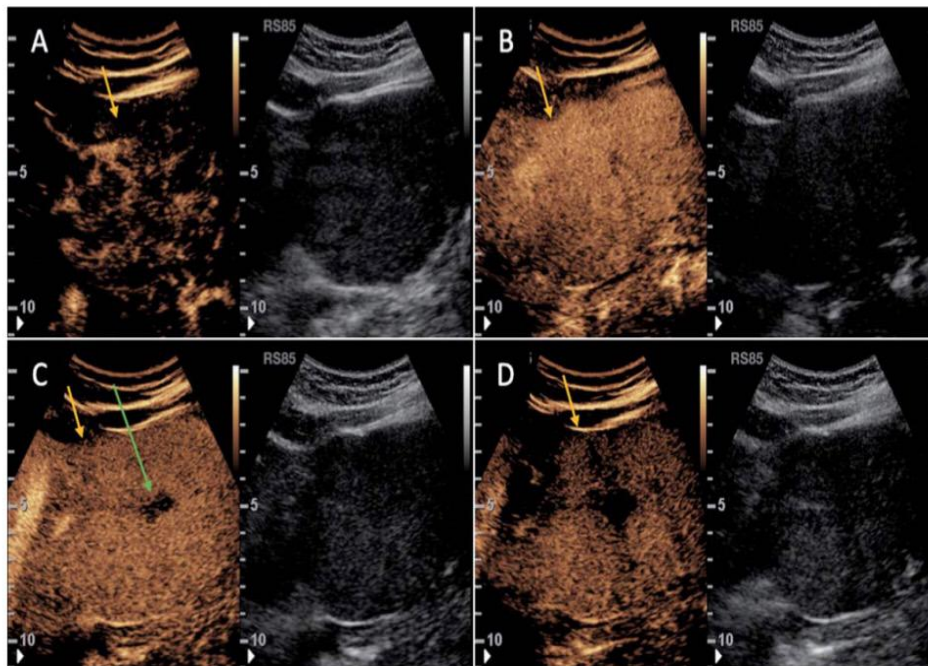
Same patient as in Figure 3. Split-screen contrast-enhanced sonograms (left panels) and B-mode US (right panels) from subcostal views demonstrate a focal nodular hyperplasia (yellow arrows) with atypical pattern. A and B: arterial phase (7-15 seconds) displays a spoke-wheel-like centrifugal filling of the lesion. C: Sustained enhancement of the lesion in the portal venous phase (90 seconds); isoechoic relative to the surrounding liver parenchyma. Hypoechoic stellated scar in the center of the lesion during the portal phase (green arrow). D: Hypoechoic of the lesion in the late phase (3 minutes after administration of contrast agent) showing an atypical pattern of the lesion.
